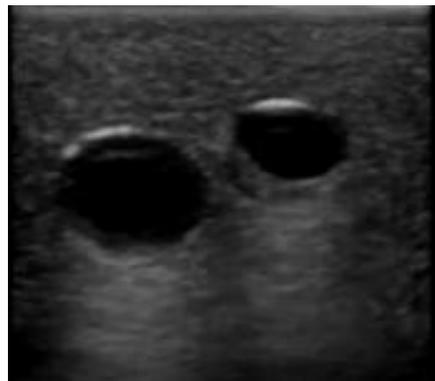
An ultrasound with a blood clot visible in the left common femoral vein
